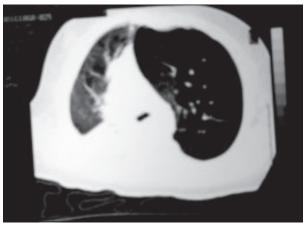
CT scan show CLE of left upper lobe.
